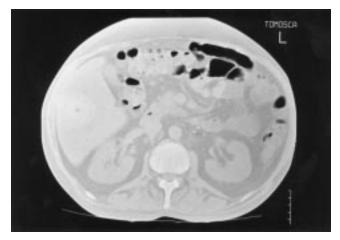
CT of the abdomen performed on day +410 after transplantation at the level of the renal hilum shows no evidence of *Pneumatosis intestinalis*, pneumoperitoneum or pneumoretroperitoneum.
